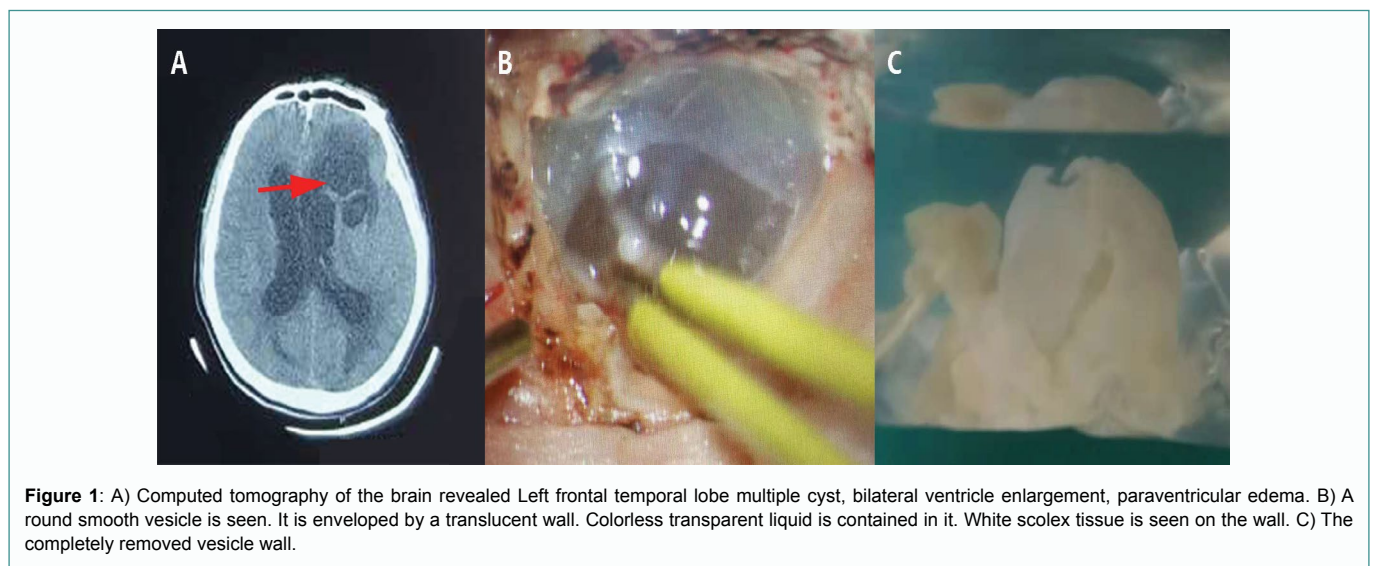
A) Computed tomography of the brain revealed Left frontal temporal lobe multiple cyst, bilateral ventricle enlargement, paraventricular edema. B) A round smooth vesicle is seen. It is enveloped by a translucent wall. Colorless transparent liquid is contained in it. White scolex tissue is seen on the wall. C) The completely removed vesicle wall.
